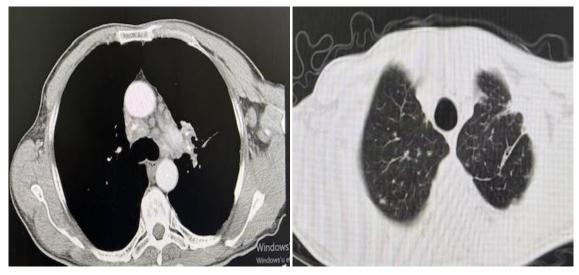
Thorax CT reveals multiple enlarged lymph nodes in the anterior mediastinum and parenchymal fibrotic lesions in the left upper lobe.
